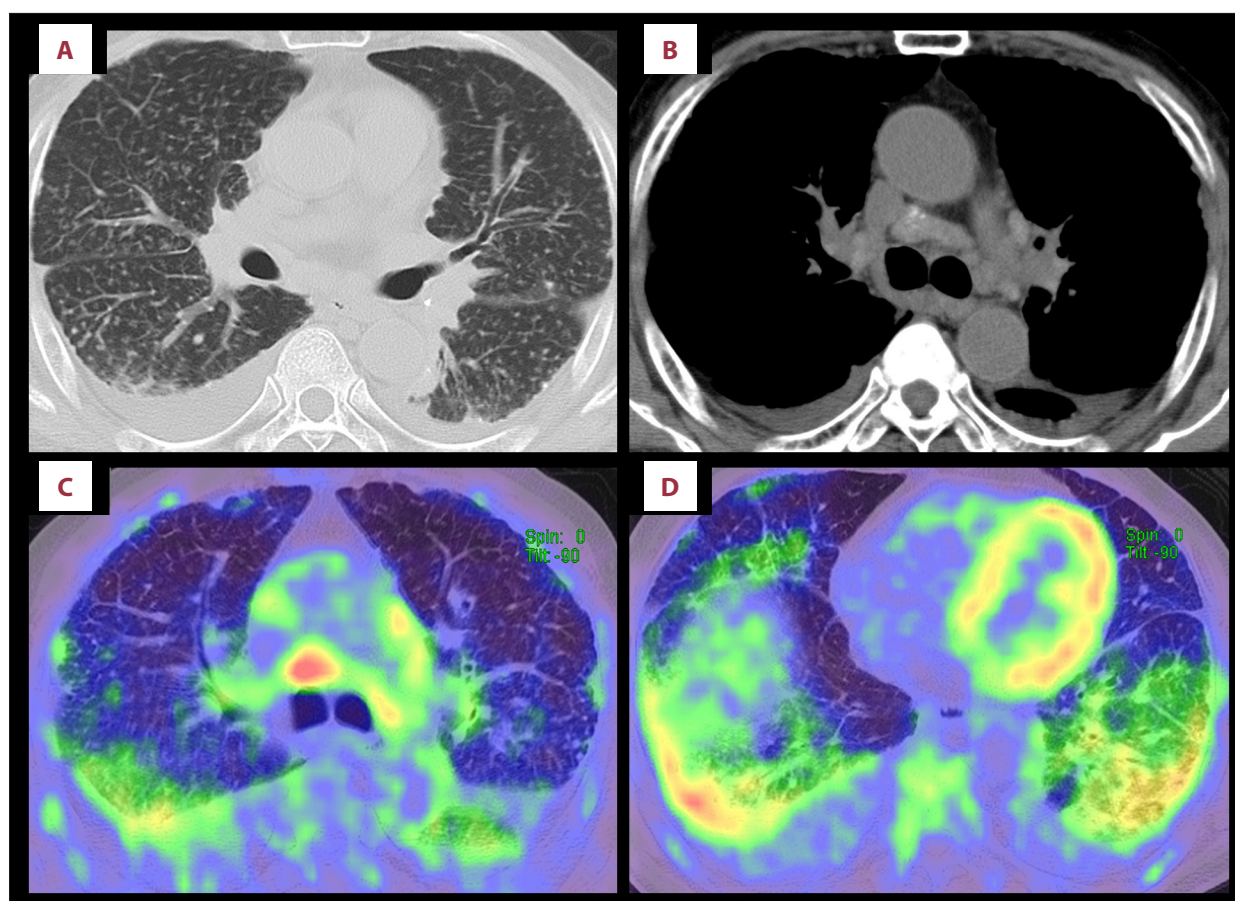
Chest CT on admission showed (A) bilateral multiple nodules with upper-lobe dominance, interlobular septal thickening, and lower-lobe-dominant consolidation with pleural effusion, and (B) mediastinal lymphadenopathy with calcification. Positron emission tomography-CT showed high 18-fluorodeoxyglucose accumulation in the (C) mediastinal lymph nodes (SUV maximum of 5.7), and (D) bilateral pleura (SUV maximum of 5.1). CT – computed tomography; PET – positron emission tomography; SUV – standard uptake value.
